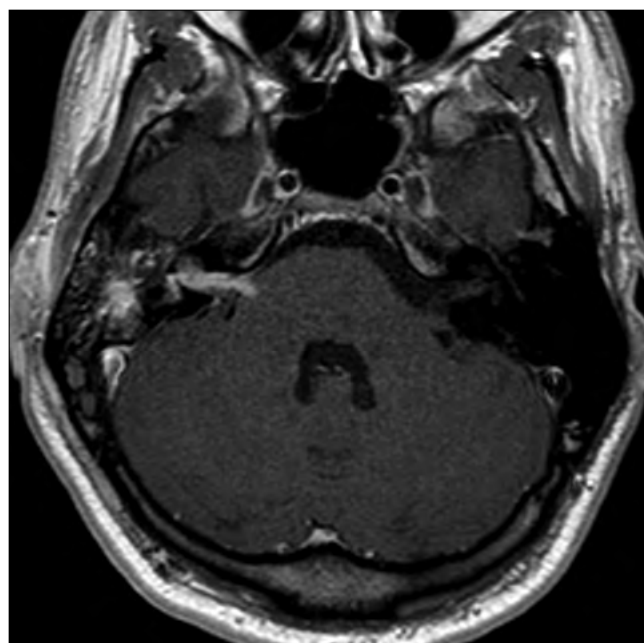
MRI imaging, T1 sequence after gadolinium infusion, axial view: gadolinium enhancement of the antrum, vestibule and internal auditory canal.
